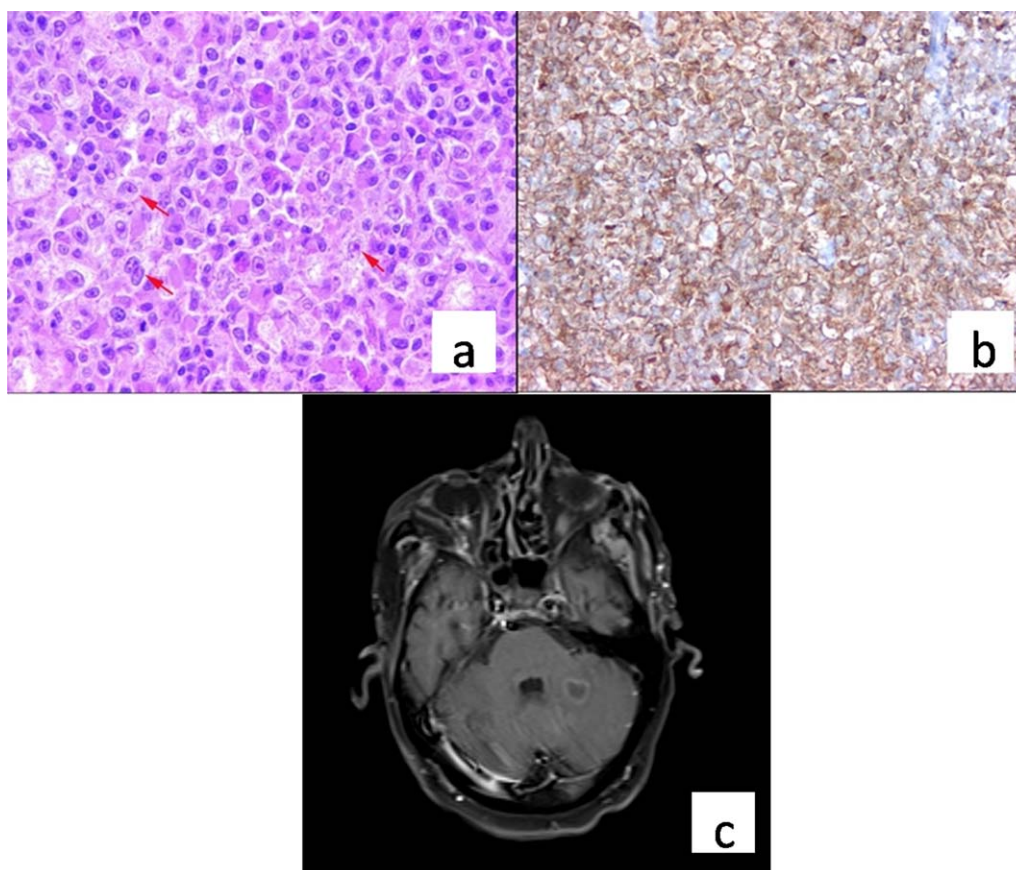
a: Diffuse infiltration by a large atypical lymphoid cell population(HE $\times 400$), b: these atypical cells were immunopositive for CD20 (CD20 $\times 200$), c: T1-weighted postcontrast transverse image shows peripherally enhancing lesion within left cerebellar hemisphere
